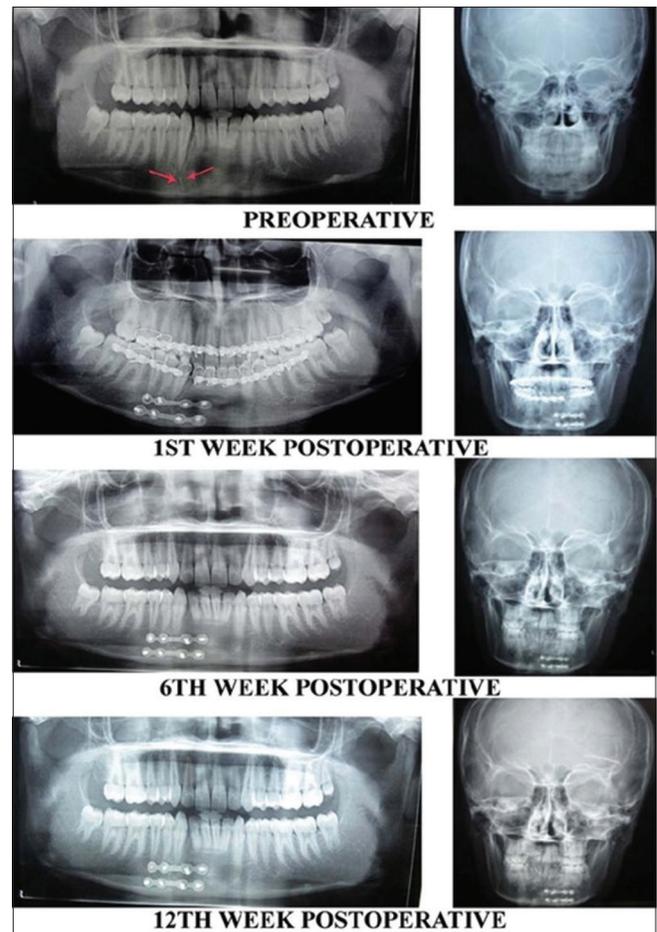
The pre- and post-operative radiographic healing in an orthopantomogram and posteroanterior view
